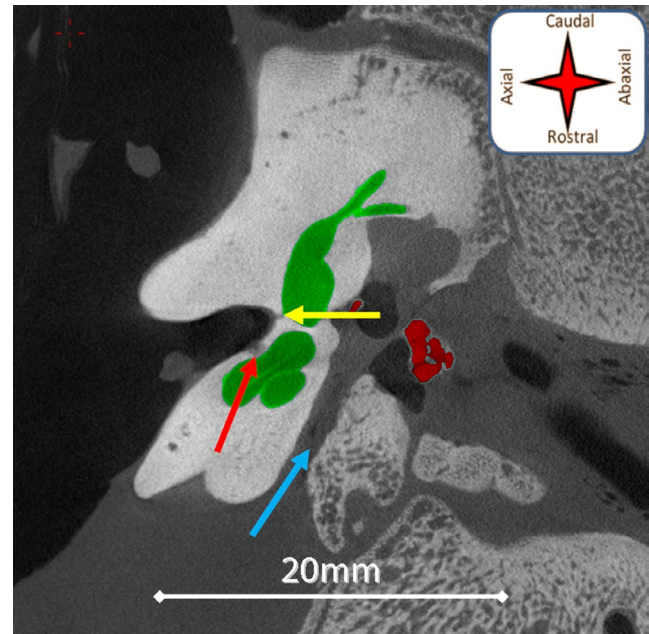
Micro-focus X-ray computed tomography 2D slice image obtained from the right ear of case 2, coronal plane. The green area shows the cochlea. The red areas highlight the stapes and the incudomalleolar joint. The facial canal (blue arrow) and tracts of the cochlear (red arrow) and vestibular (yellow arrow) nerves are visible. IAM: Internal acoustic meatus
